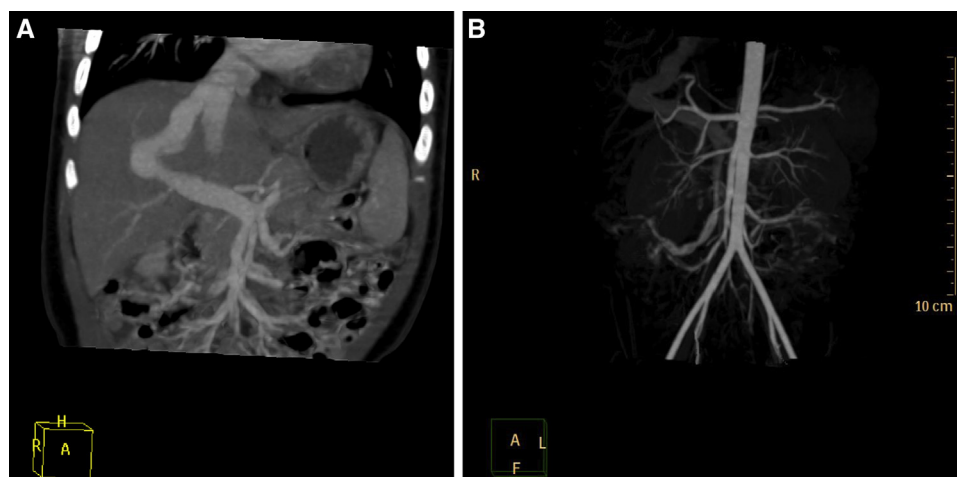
CTA of the abdomen showing hypoplastic intrahepatic portal branches.
